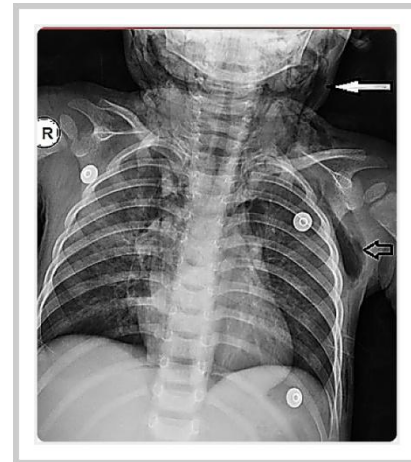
Posteroanterior chest radiograph reveals air collections surrounding the mediastinal structures and marked subcutaneous emphysema in the neck region and left chest wall (black and white arrows). A minimal extrapleural air is also noted adjacent to the fourth lateral rib.
